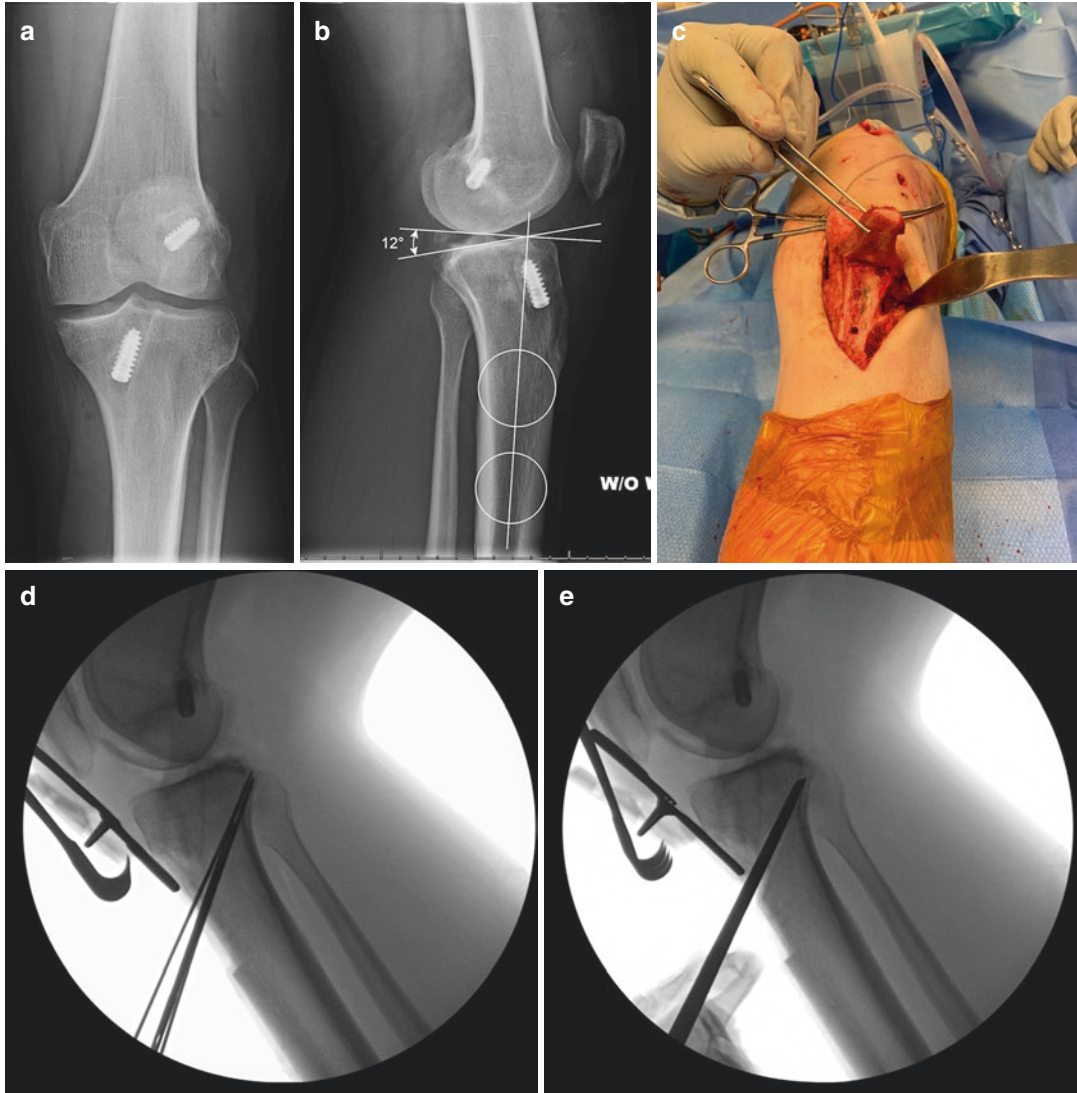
Combined HTO and ACLR for multiple ACL failures. (a, b) AP and sagittal X-rays of multiply revised ACL-reconstructed knee, again ACL deficient, with posterior tibial slope of 12° . (c) A tibial tubercle osteotomy is performed to access the HTO site of the anterior tibial cortex. (d, e) Intra-operative radiographs of slope-correcting
